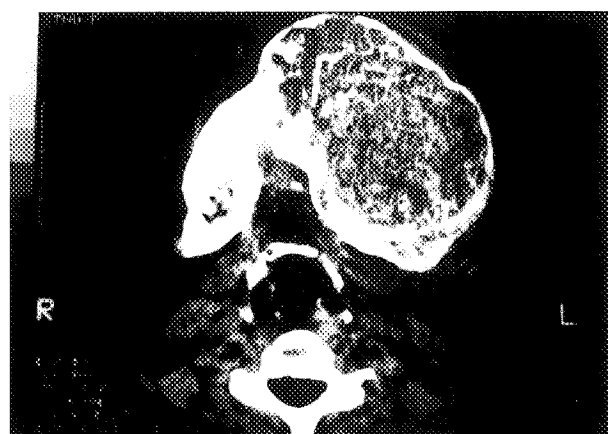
Preoperative axial CT scan at level of mandible.
